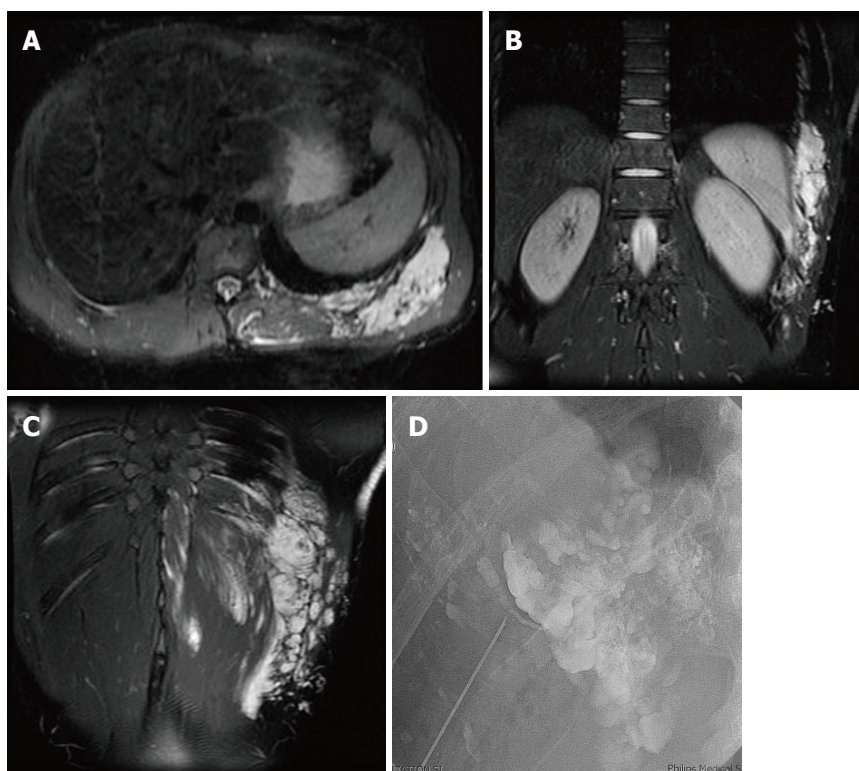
Foam sclerotherapy is ideal for treatment of low flow venous vascular malformations. Axial and coronal T2 weighted magnetic resonance images demonstrate a low flow venous malformation of the chest and upper abdominal wall (A, B, C). Direct access venography with a 22-gauge needle shows foamed STS opacified with contrast filling the malformation (D).
